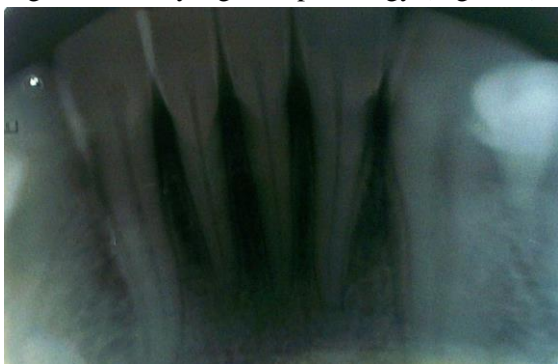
Preoperative radiograph of the teeth associated with the lesion showing no signs of pathology
